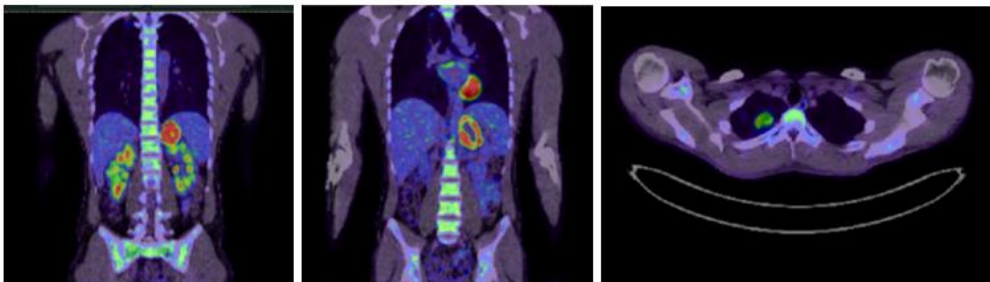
FDG-positron emission tomography / computed tomography
